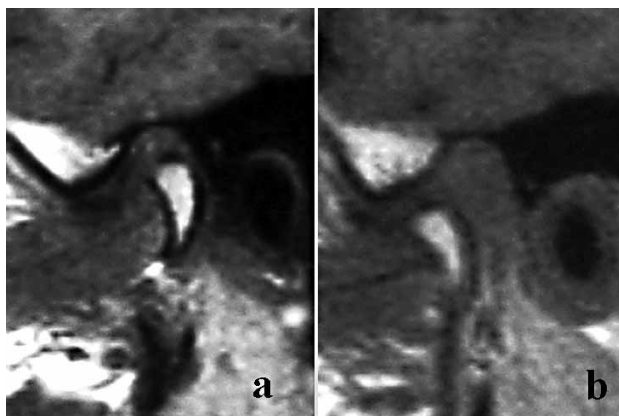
MRI showing TMJ of a 38-years old male patient with DD (a, closed mouth). In the open mouth position (b) a reducible disc on deplained condyle, which is extremely hypomobile, it seen.
